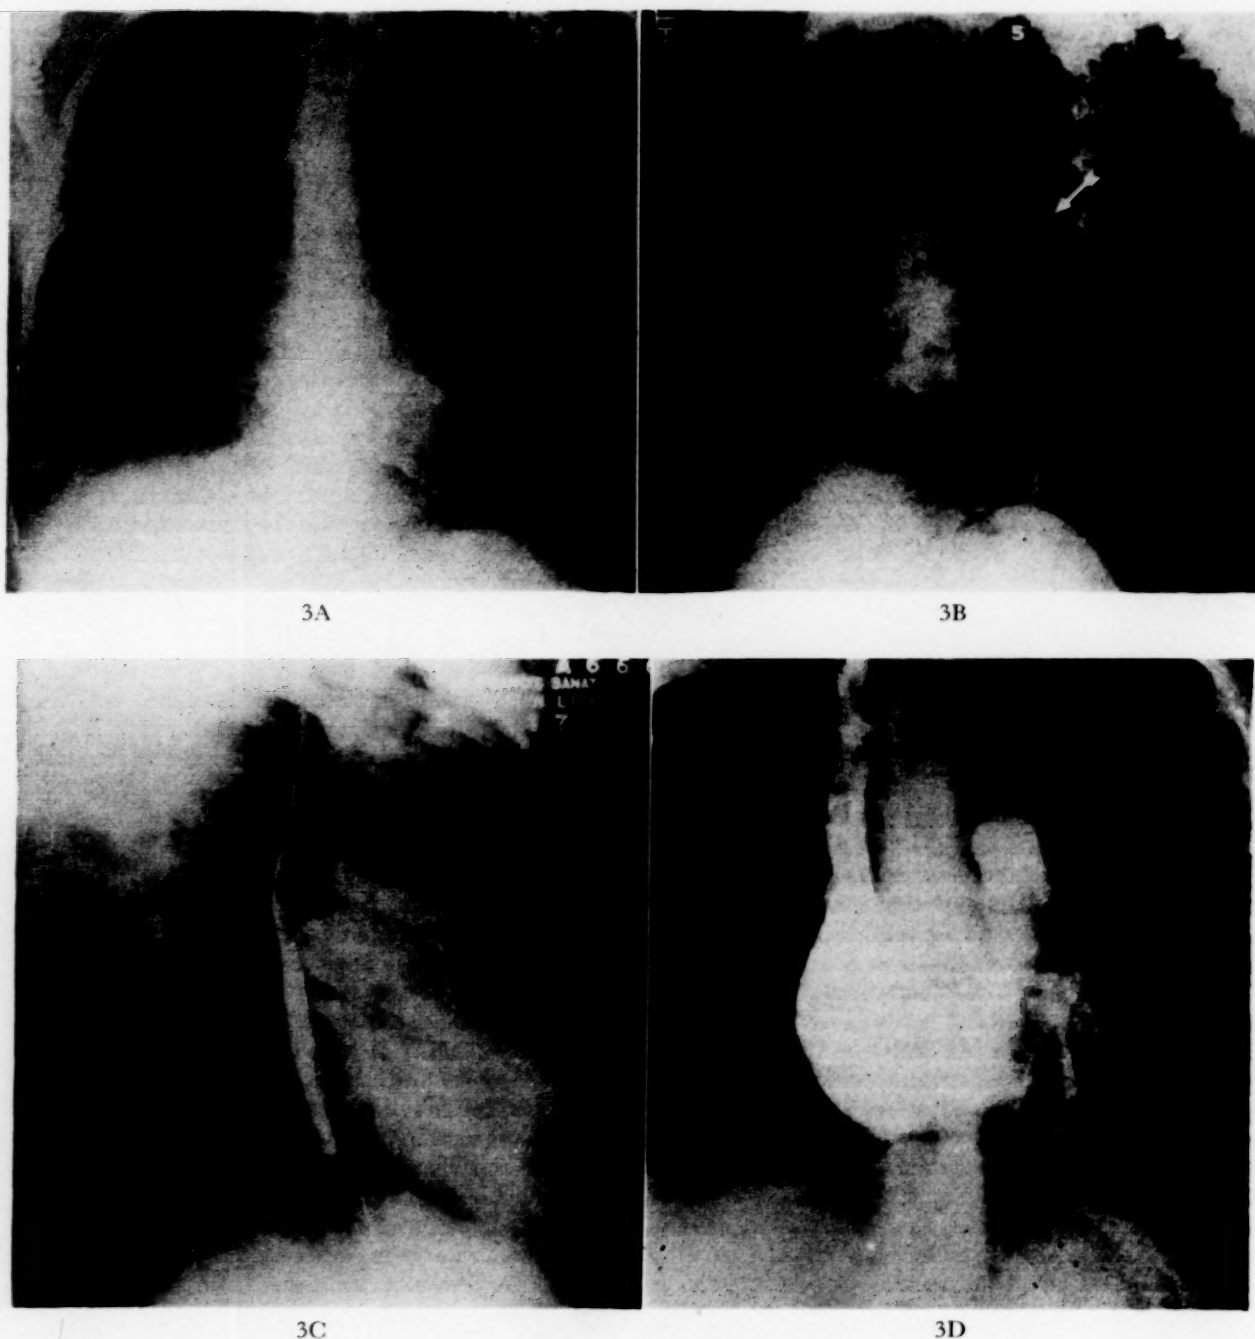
to D. CASE III. A, frontal roentgenogram shows heart enlargement. Left pulmonary artery and tree appear normal. The right pulmonary vasculature is diminished. The right lung is slightly smaller than the left; the heart and mediastinal structures are in the mid-line. B, left anterior oblique position shows a left pulmonary artery (arrow); the right cannot be seen. C, the right anterior oblique esophagram suggests absence of the right pulmonary artery. D, frontal angiogram showing absence of a right pulmonary artery.
